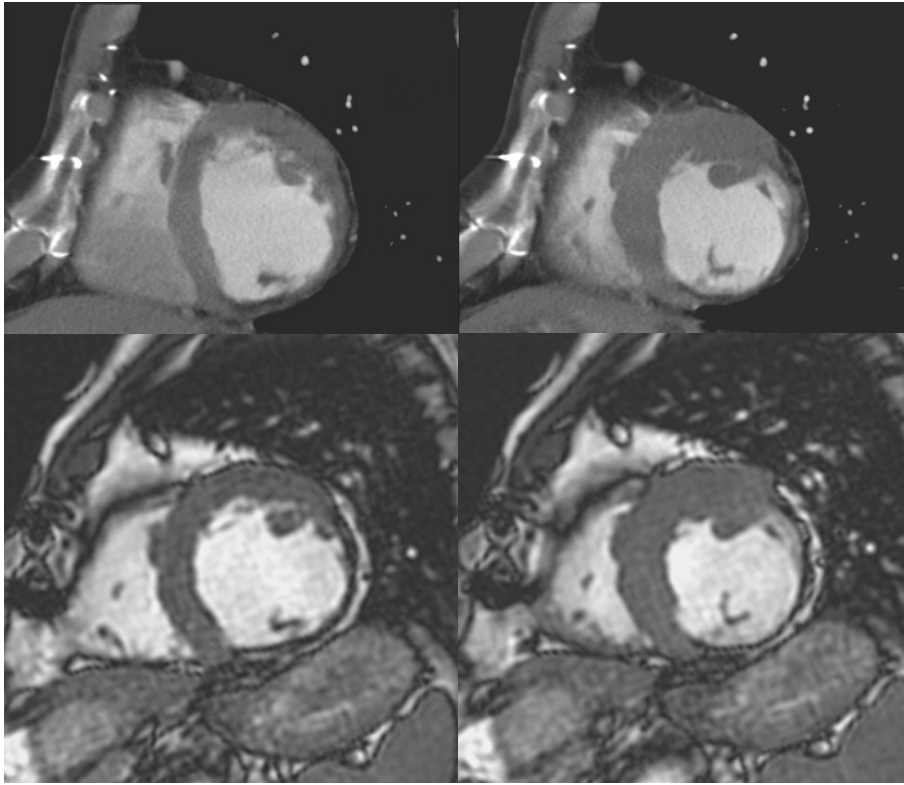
16-slice CT study from a 64-year-old male patient with 2-vessel coronary artery disease who underwent bypass surgery. Diastolic (left column) and systolic (right column) short-axis reformations from 16-slice CT (upper row) and cine magnetic resonance imaging (CMR, lower row) studies demonstrate reduced left ventricular diastolic myocardial wall thickness and absent systolic wall thickening in the lateral and inferior myocardium. calculation of the left ventricular ejection fraction (LVEF) with 16-slice CT and CMR correspond well (LV-EF by 16-slice CT = 60.6%, LV-EF by CMR = 61.7%)
